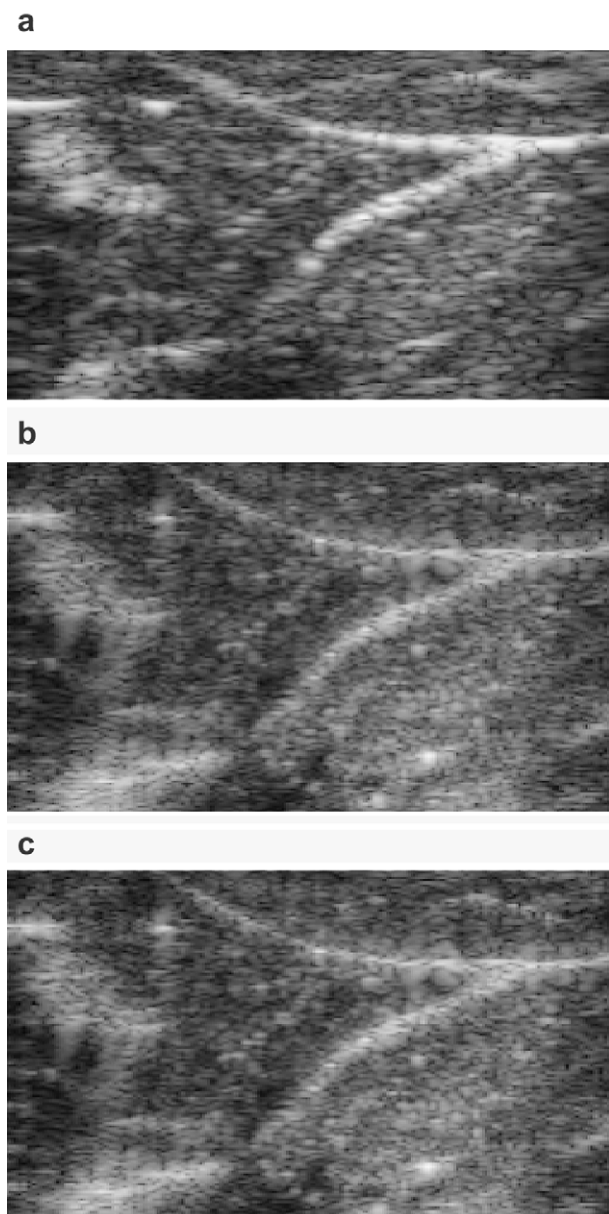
Ultrasound images of an *in vivo* human forearm: (a) original ultrasound image, (b) deconvolution by an optimum speed of 1571.74 m/s and (c) deconvolution by a nominal speed of 1540 m/s. The size of the images is 14.6 mm \times 25.0 mm, when the speed of sound is assumed to be 1540 m/s for comparison purposes. The ultrasound data set is the same as that used in Figure 11. The dynamic range of the logarithmically compressed images is 60 dB.
